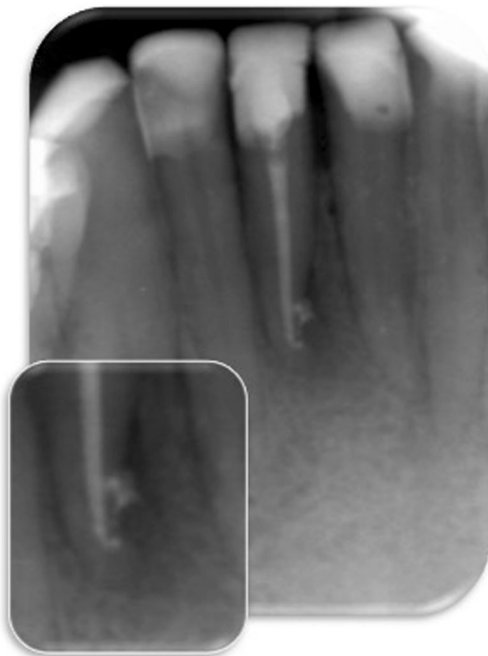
Case #1 radiographic assessment with a 6-month follow-up
